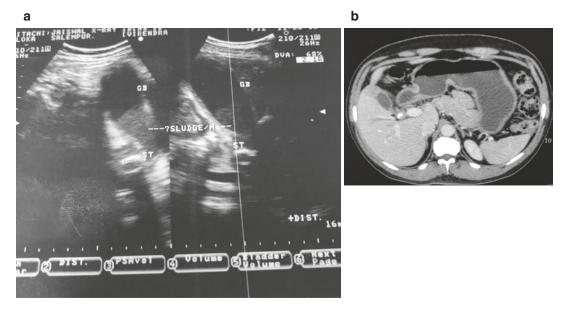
(a) US shows gall bladder sludge (no distal acoustic shadowing). (b) CT showed that it was not sludge but a gall bladder mass
